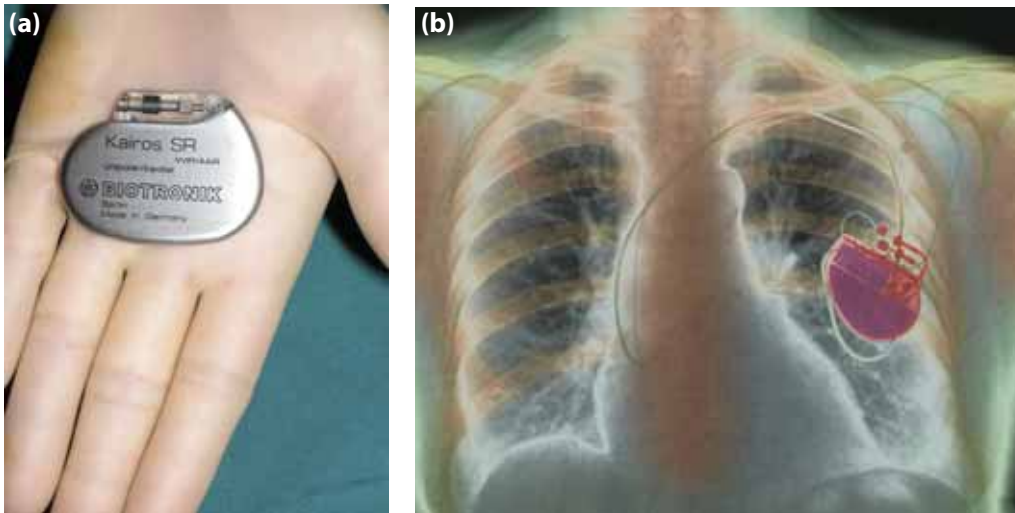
(a) A pacemaker; (b) an X-ray of a pacemaker in place in a person's chest
